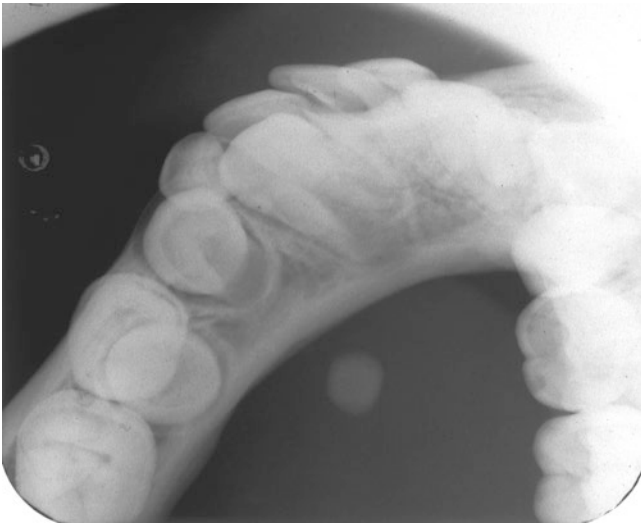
Intraoral dental radiograph showing a radiopaque calculus in the submandibular area
